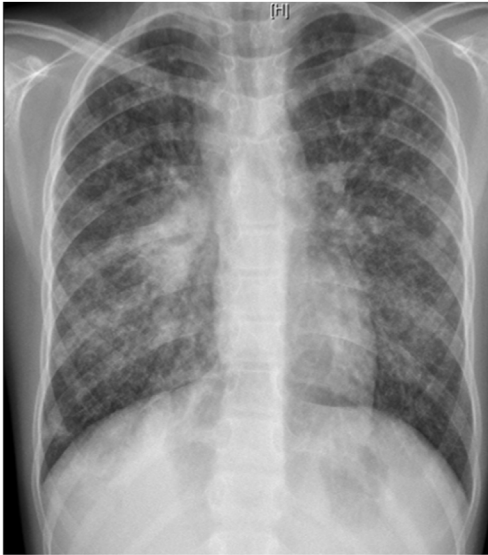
Chest X-ray: diffuse alveolo-interstitial opacities, with right parahilar consolidation with central cavitation.
